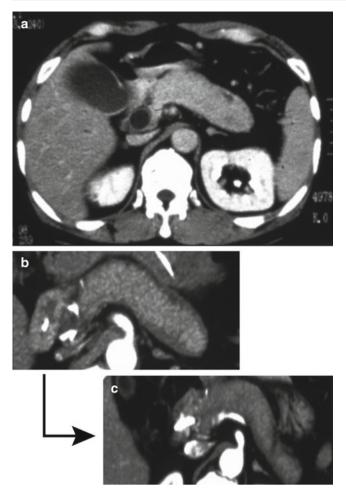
Abdominal CT images of autoimmune pancreatitis (diffuse swelling). (a) Pancreatic swelling and delayed enhancement (sausage like). (b) Capsule-like low-density rim. (c) after steroid
